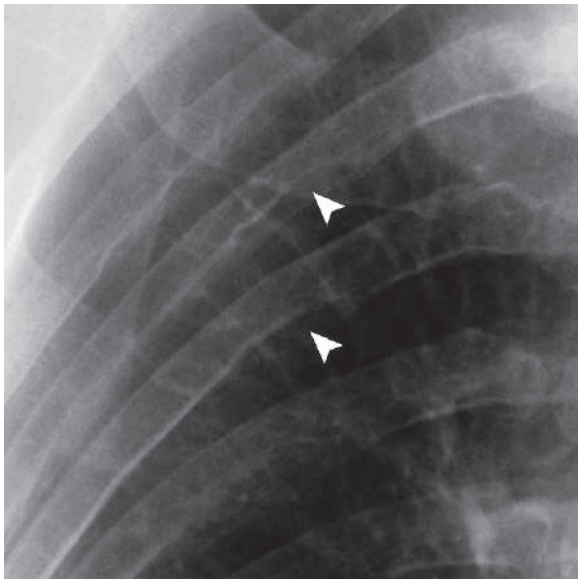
Plain chest radiograph shows rib notching in a patient with severe aortic coarctation since 12 years (*arrowheads*)
